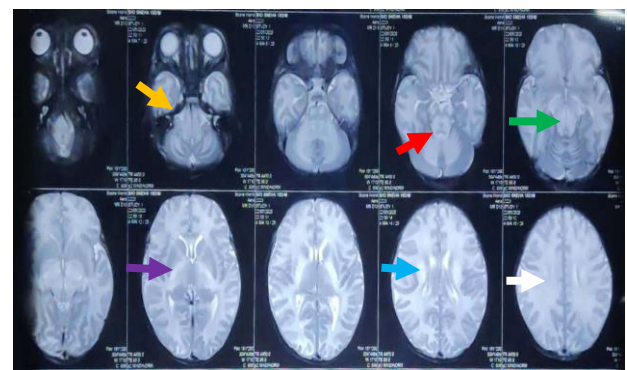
MRI brain T2 axial, T2 hyperintensities in bilateral perirolandic white matter (white arrow), corticospinal tracts (green arrow), corona radiata (blue arrow), thalamo-ganglionic region (purple arrow), brain stem (yellow arrow) and deep cerebellar white matter (red arrow).
